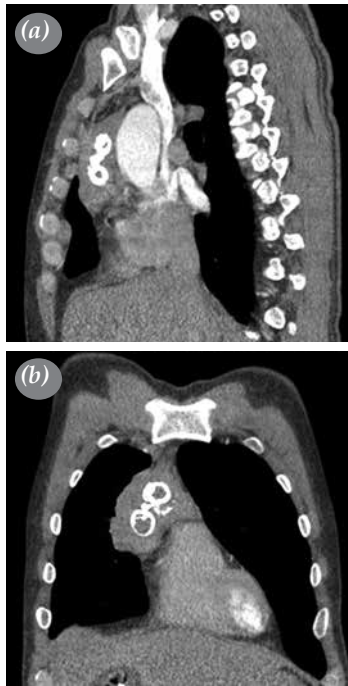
Retrosternal calcified mass is seen in the sagittal (a) and coronal (b) contrast-enhanced thoracic computed tomography images.
